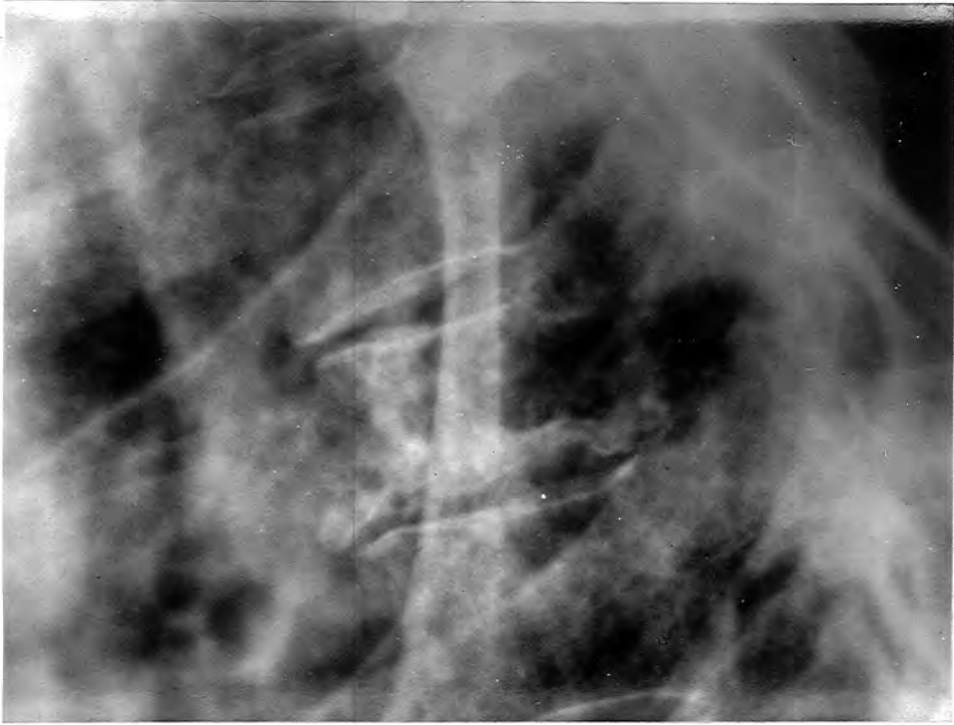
CASE FIFTEEN. X-ray thoracic spine, lateral view. Partial collapse of T.5 with excavation of posterior part of the body.
